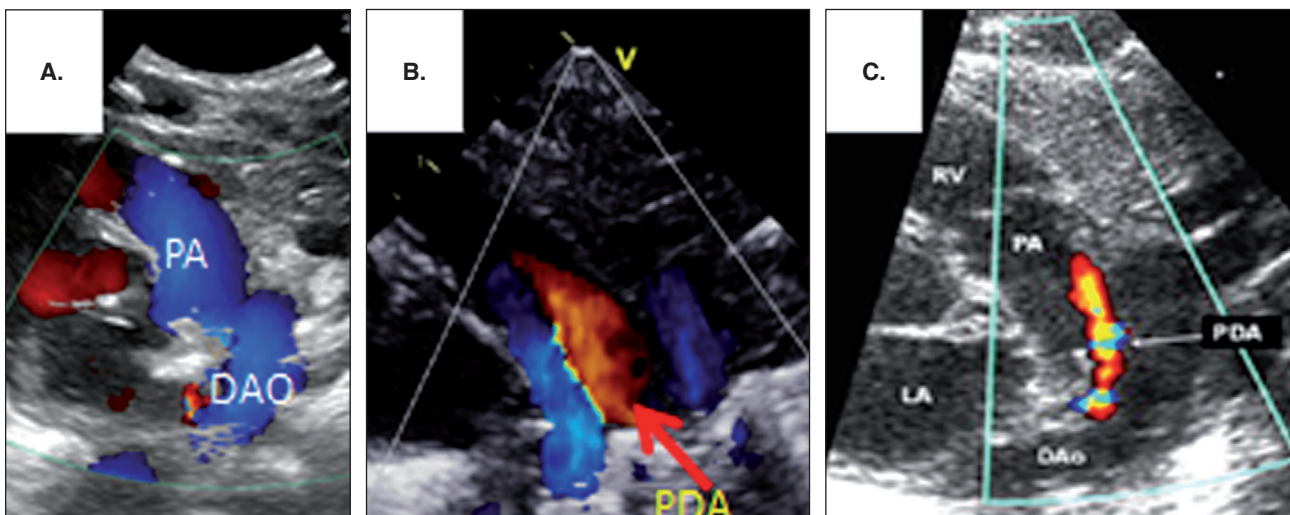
High parasternal view (ductal cut). A. No PDA by color between PA and DAO. B. Large PDA pattern C. Closing PDA pattern.
